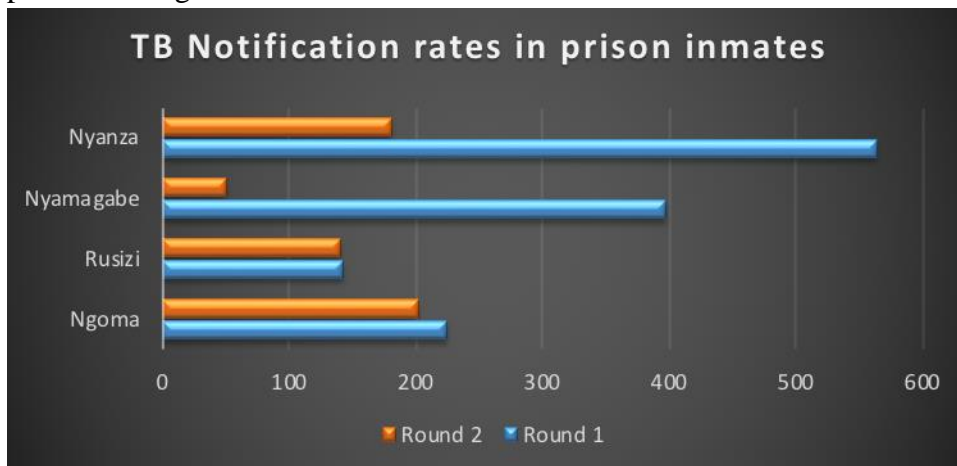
Results of two rounds of ACF using x-ray for screening in four prisons during FY 2017-2018.
